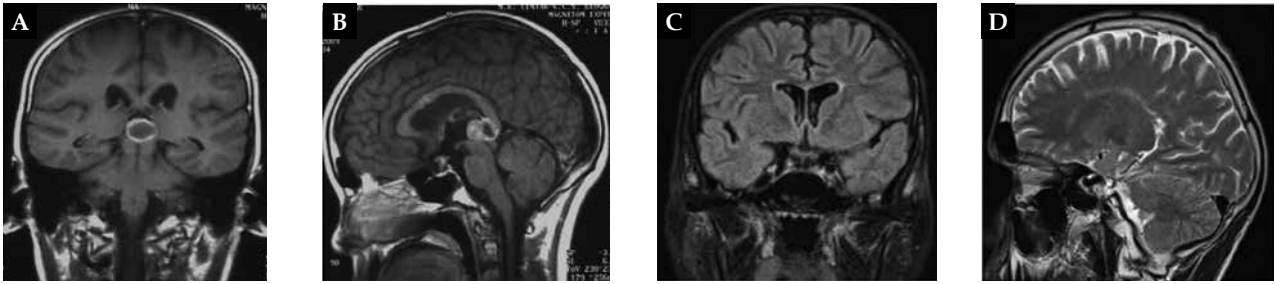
Preoperative MRI of Patient 2 showed tumour in the third ventricle and pineal region, with hydrocephalus and dilatation of both lateral ventricles; C, D. MRI of Patient 2, seven years after radiotherapy and chemotherapy and two years of GH replacement, shows no signs of tumour recurrence
